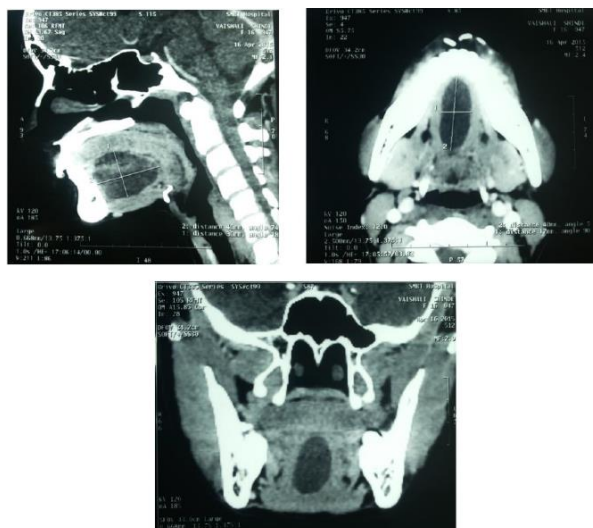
The computed tomography (CT) of the submental area showing a well defined radiolucency with distinct borders.
